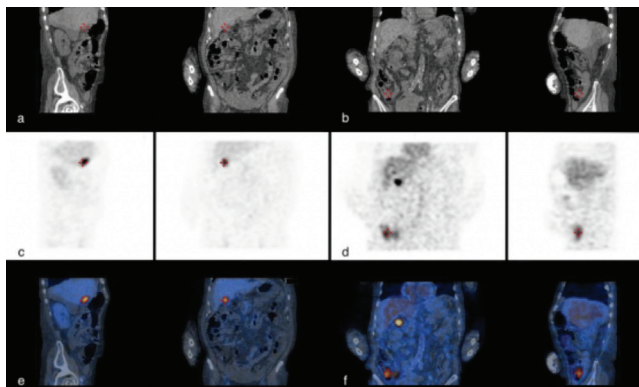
1st (a, c, e) and 6th hour (b, d, f) CT, SPECT and fusion SPECT/CT images of a patient with gallbladder visualisation
